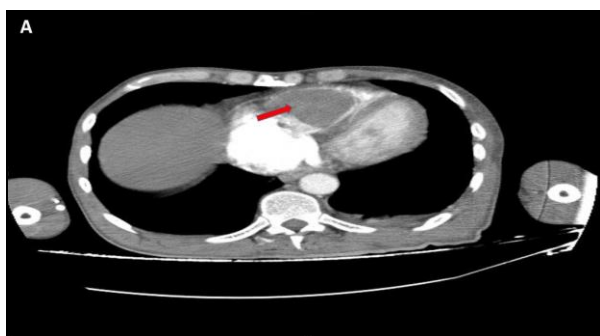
Axial Thoracic Imaging by Computed Tomography Imaging at Diagnosis. A, Right Ventricle Thrombus (Red Arrow). B, Right Atrial Thrombus (Red Arrow).
